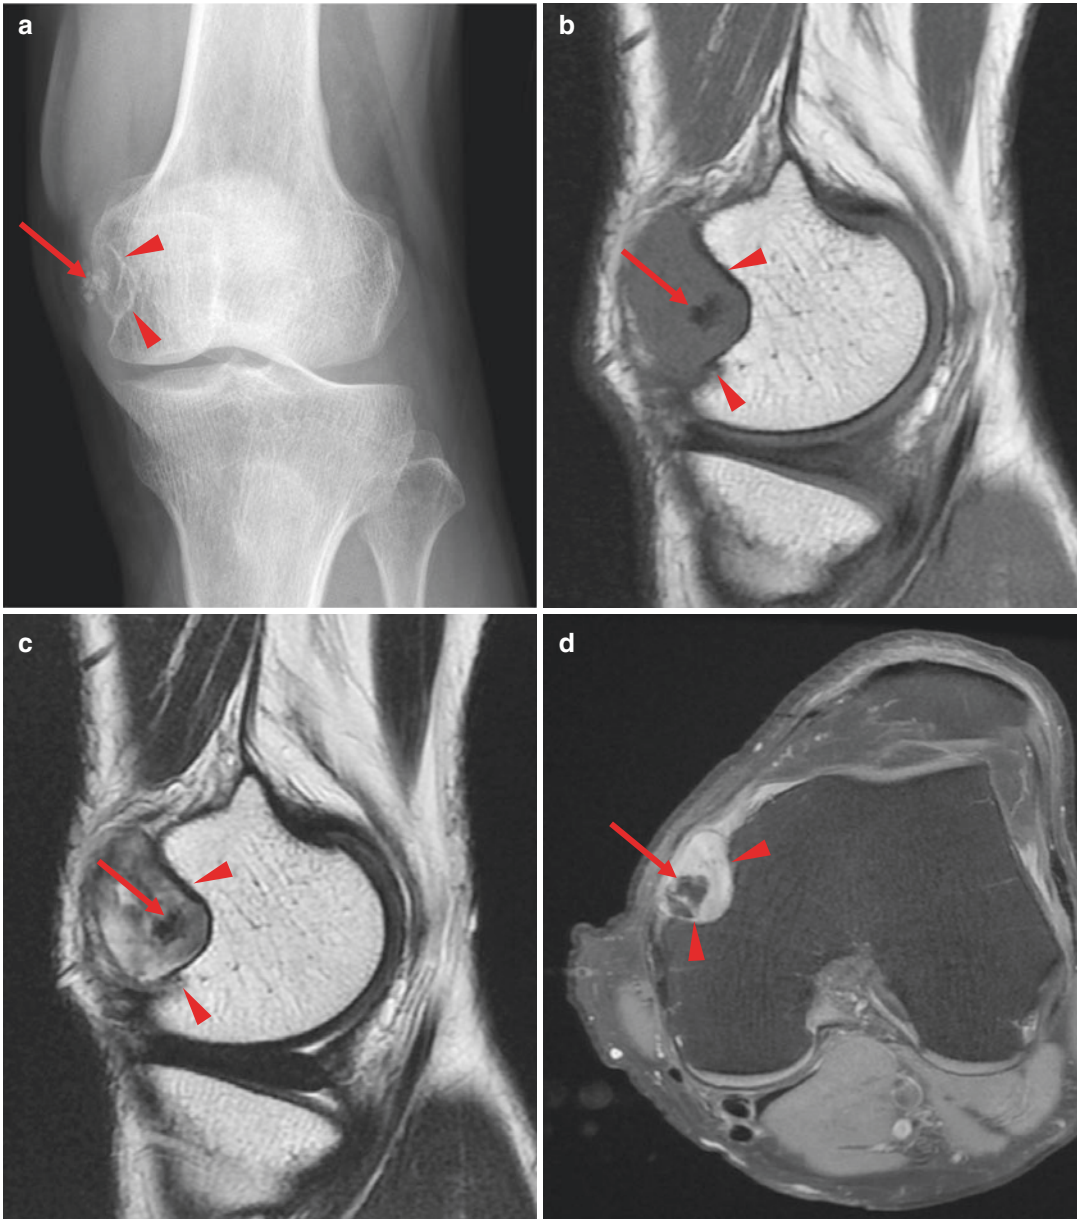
Leiomyoma of deep soft tissue. Radiograph (a) shows an intra-articular soft tissue mass medial to the medial femoral condyle. The tumor is isointense to muscle on sagittal T1WI (b) and has mixed signal intensity on T2WI (c), ranging from hypointensity to hyperintensity.
